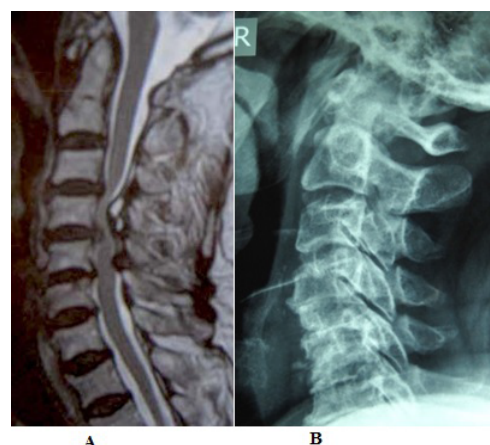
MRI showing C4-C5, C5-C6 spondylotic myelopathy (A) C4-C5, C5-C6 fusion after ACDF with tricortical iliac bone graft at 1 year follow up (B).
